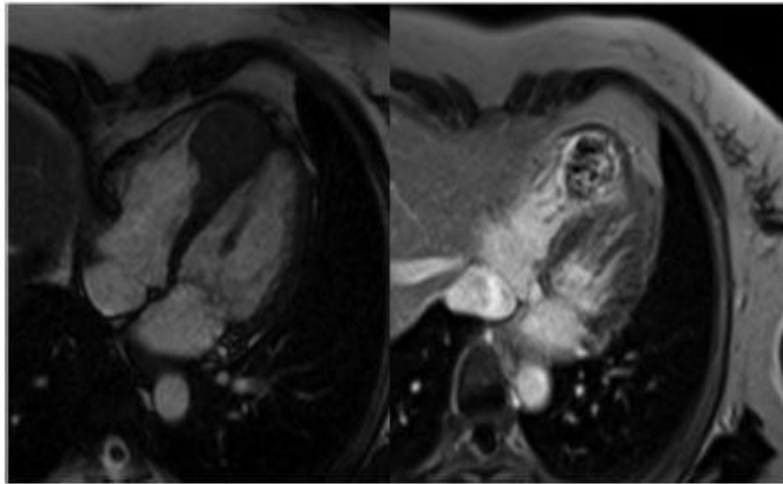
Cardiac MRI performed before radiotherapy, showing a lesion of 41-mm developed from right ventricle with hyposignal on T2 sequence (left) and peripheral enhancement after gadolinium injection and necrotico-hemorrhagic changes on T1 sequence (right).
